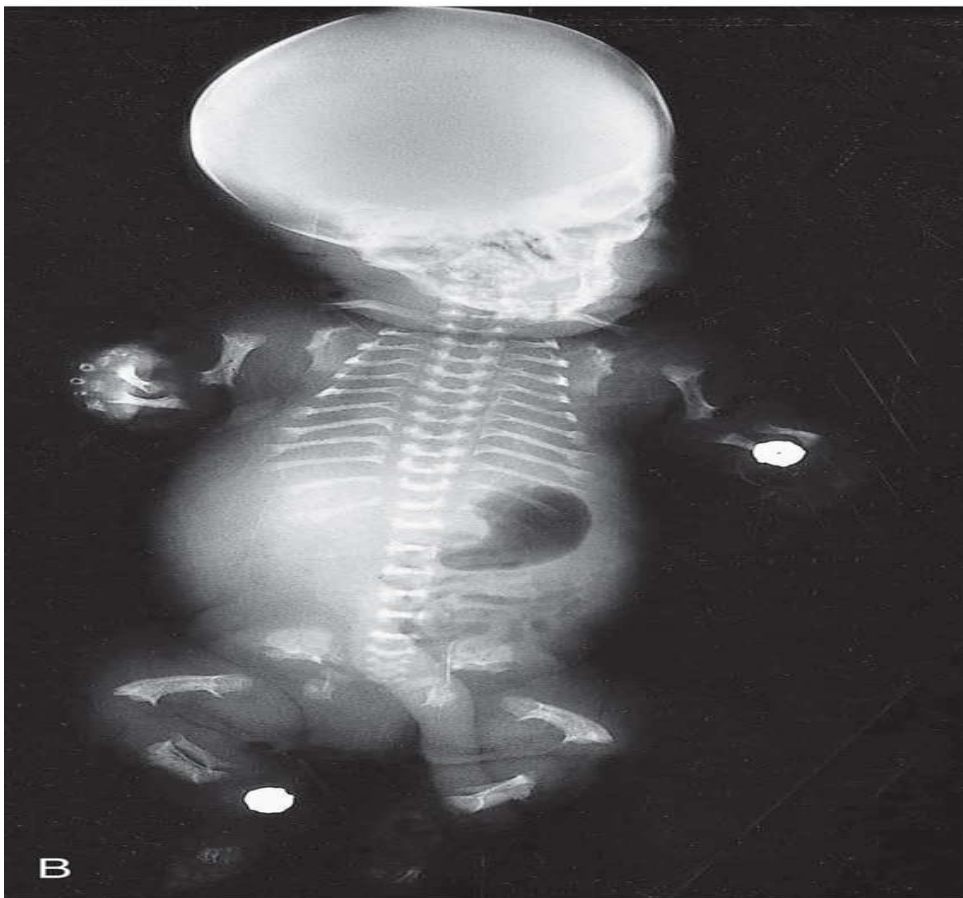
(A) Infant with thanatophoric dysplasia. (B) Radiograph of the infant showing short ribs, flat vertebral bodies, and curved femora.
